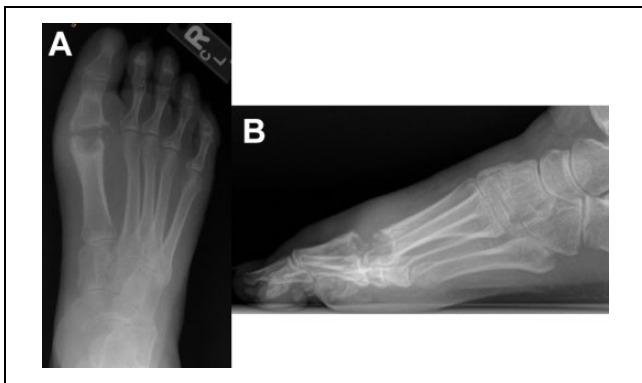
(A) Anteroposterior and (B) lateral radiographs of a right foot status post implantation of a synthetic cartilage implant. Imaging demonstrates ballooning osteolysis about the first MTP joint space. MTP, metatarsophalangeal.
